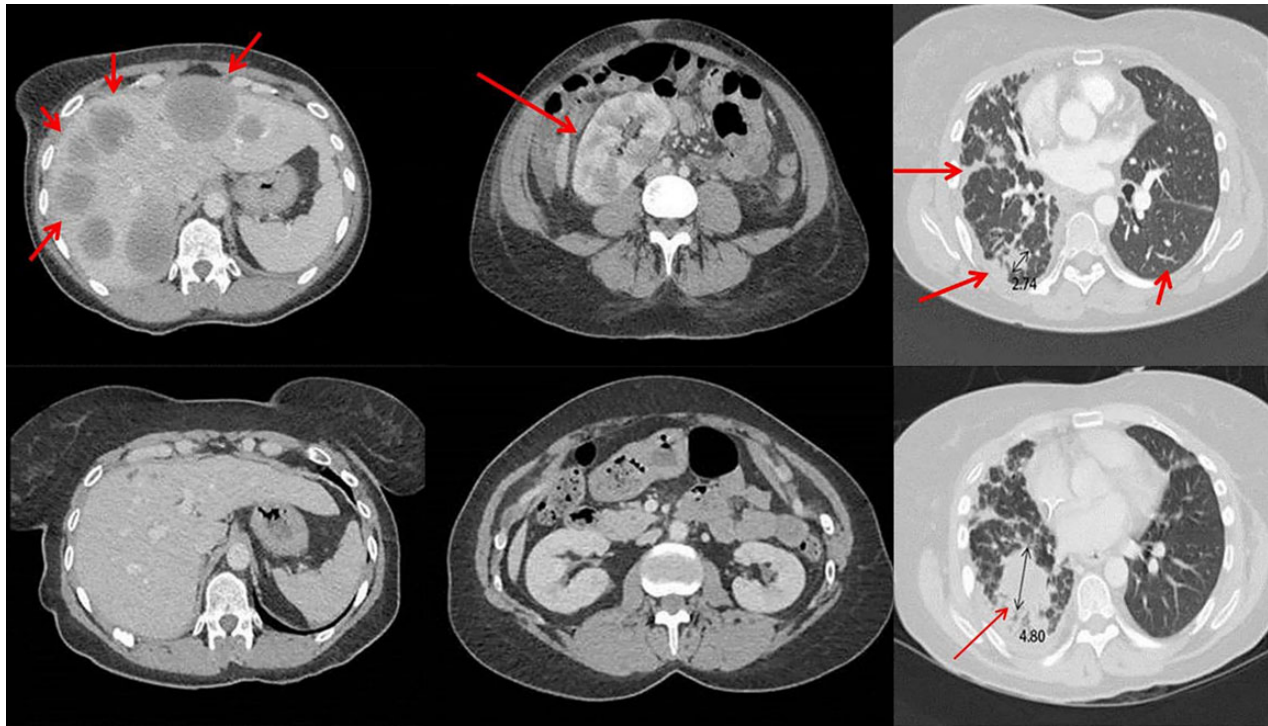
Comparison between CT scan slices of the liver, kidneys and lungs, respectively, pre- (above images) and post- (below images) chemotherapy showing remission of the PTLD after four cycles of rituximab-based chemotherapy. The interval CT scan shows progression of the PTLD in the right lung with a tumour diameter increasing from 2.4 cm to 4.8 cm despite treatment with rituximab and chemotherapy. The arrows indicate the location of the tumours. CT: computed tomography.
